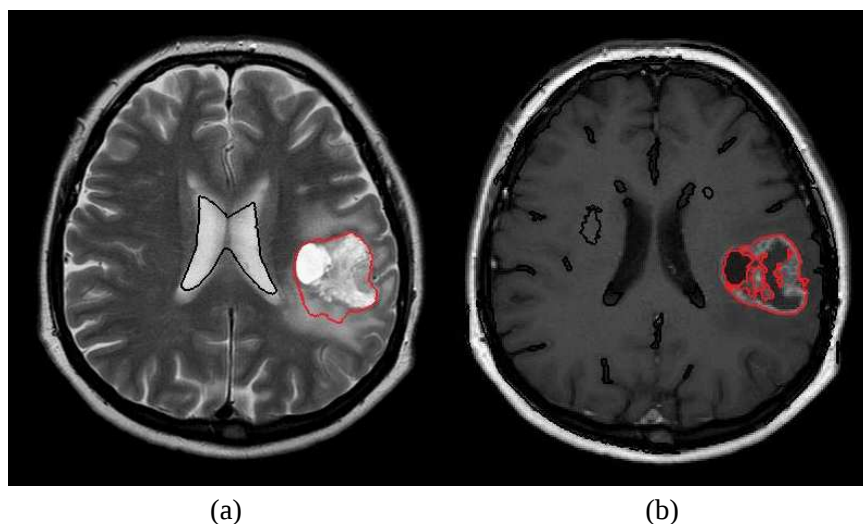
The result for incorrect brain tumor segmentation performed with the single-parametric approach. (a) Tumor segmentation in a T2-weighted image; (b) tumor segmentation in a T1-weighted image.
